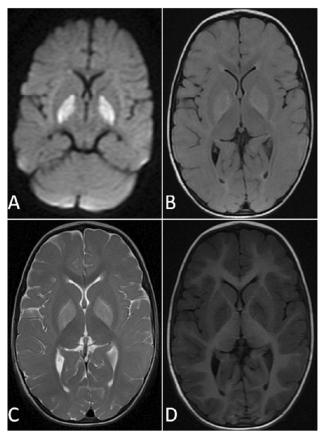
A Two-year-old term female child bought to the hospital with seizures and a history of foreign body inhalation that caused asphyxia. The patient underwent MRI scan (A) Diffusion-weighted image shows symmetrical areas of restricted diffusion in bilateral globus pallidi (B) Axial FLAIR and (C) Axial T2-weighted images demonstrating markedly increased signal intensities in bilateral globus pallidi with low signal intensities on corresponding T1-Weighted image.
